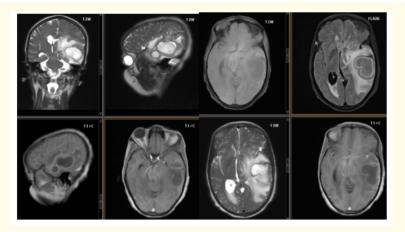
MRI a large irregular intra-axial lobulated left temporal parietal lobe mass peripheral enhancing with central non enhancing suggesting necrosis present. The mass is surrounded by edema and exerts positive mass effect and causes subfulcine herniation to the right of 1.01 cm and ipsilateral lateral ventricle effacement. Features are suggestive of Glioblastoma (GBM).
